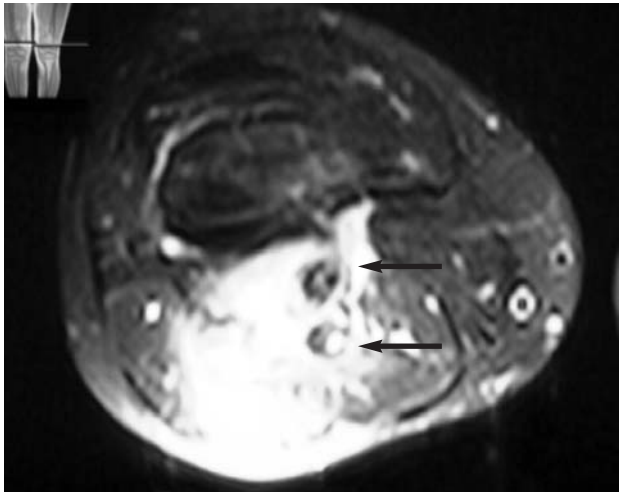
Local recurrence is shown in the same area in axial T2 weighted MRI image. Arrows show synthetic graft.
